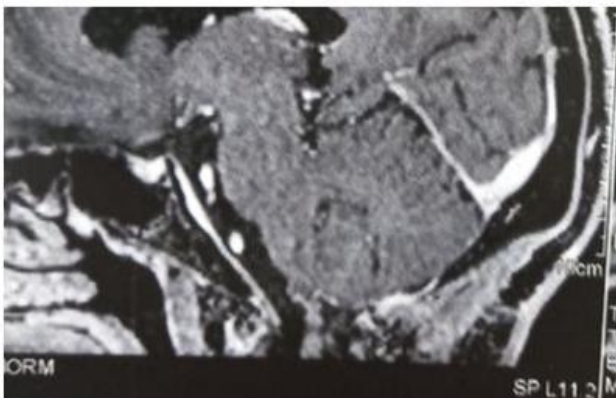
Control MRI after 3 months
